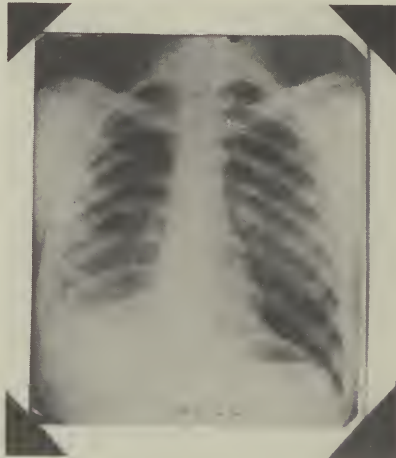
Roentgenogram two weeks after total pulmonary decortication. Complete pulmonary re-expansion and primary cure.
